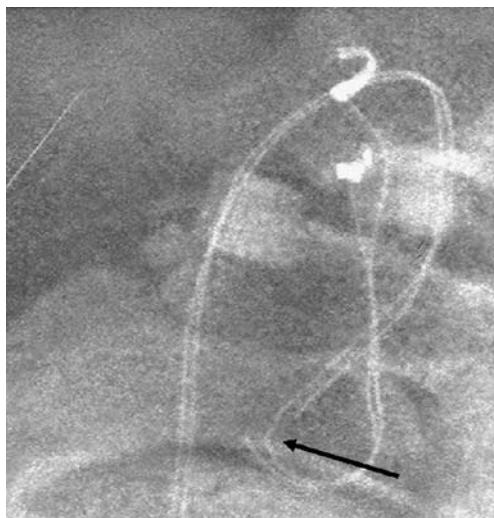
X-ray examination showing lead fracture
